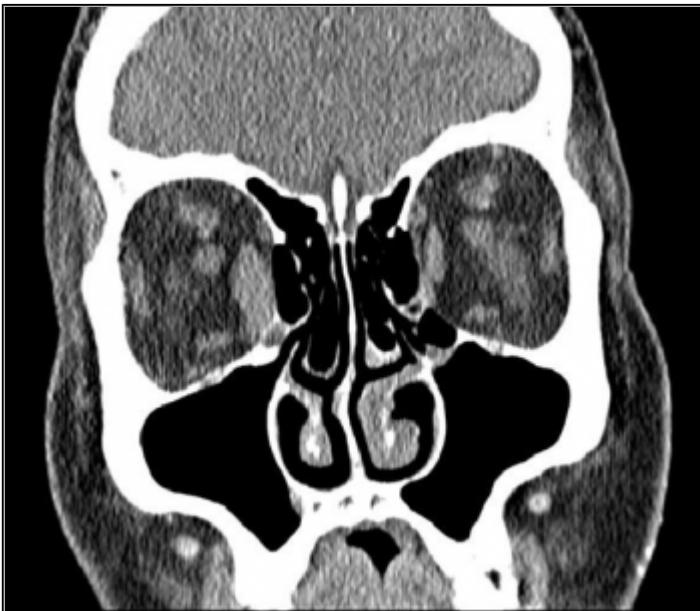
Orbits contrast-enhanced CT scan
